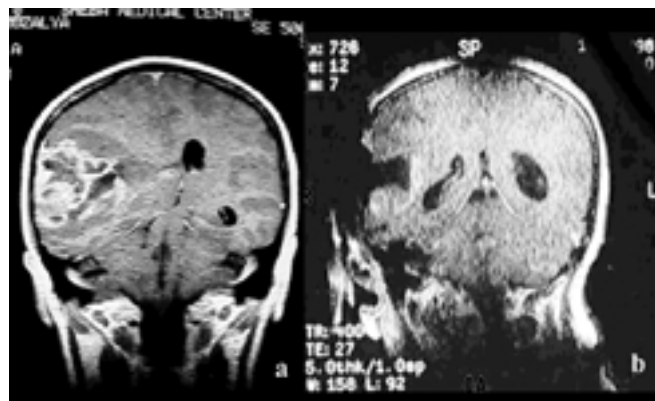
Real-time MRI images generated during surgical resection of an extensive right hemispheric anaplastic oligodendroglioma in the open iMRI (interventional MRI). [a] Preoperative coronal MRI scan after injection of gadolinium, showing the large enhancement.
